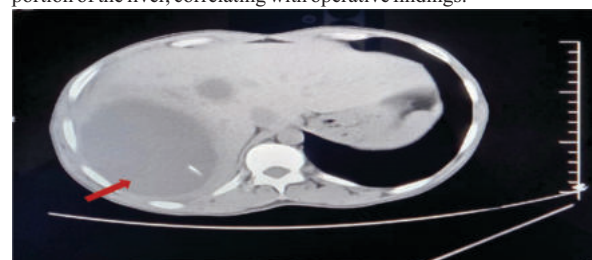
CT scan showing multiple hepatic hydatid cyst (Red arrow) :
